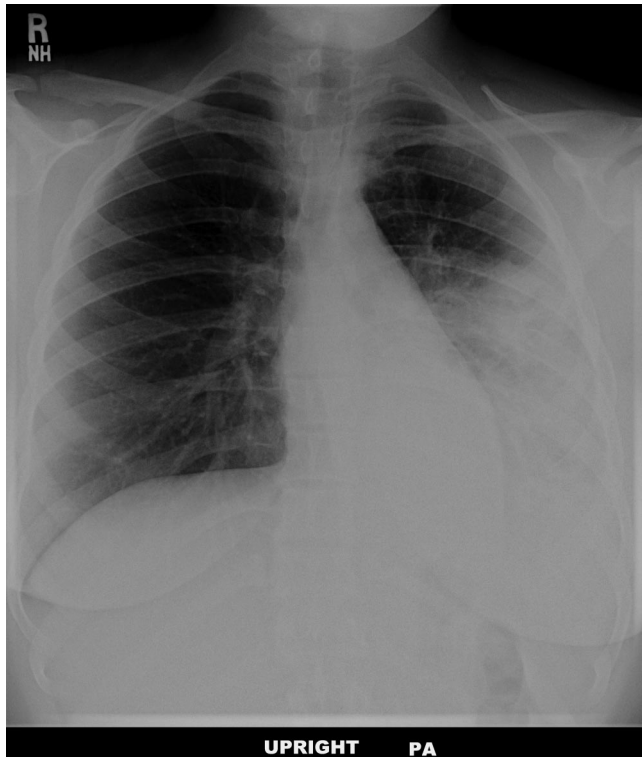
Chest radiograph. Chest radiograph revealed left lower-lobe consolidation with air bronchograms and a normal cardiothymic shadow.
